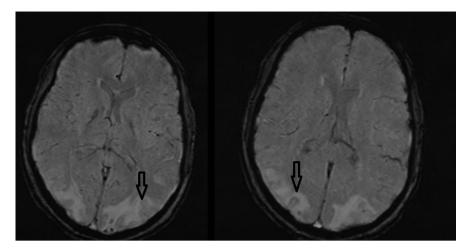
MRI brain showing bilateral occipital, parietal and subcortical white matter hyperintensities.
